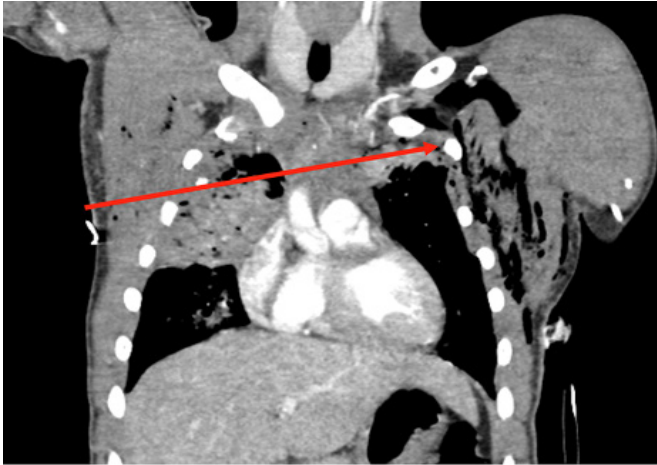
Coronal CT image of patient with Transmediastinal gunshot wound. Solid red line depicts bullet trajectory based on tissue injury on CT scan.
